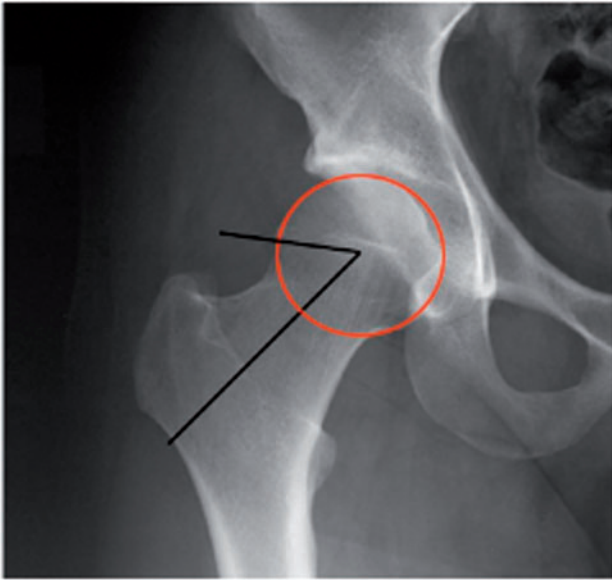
Alpha angle measurement using AP hip radiograph.
